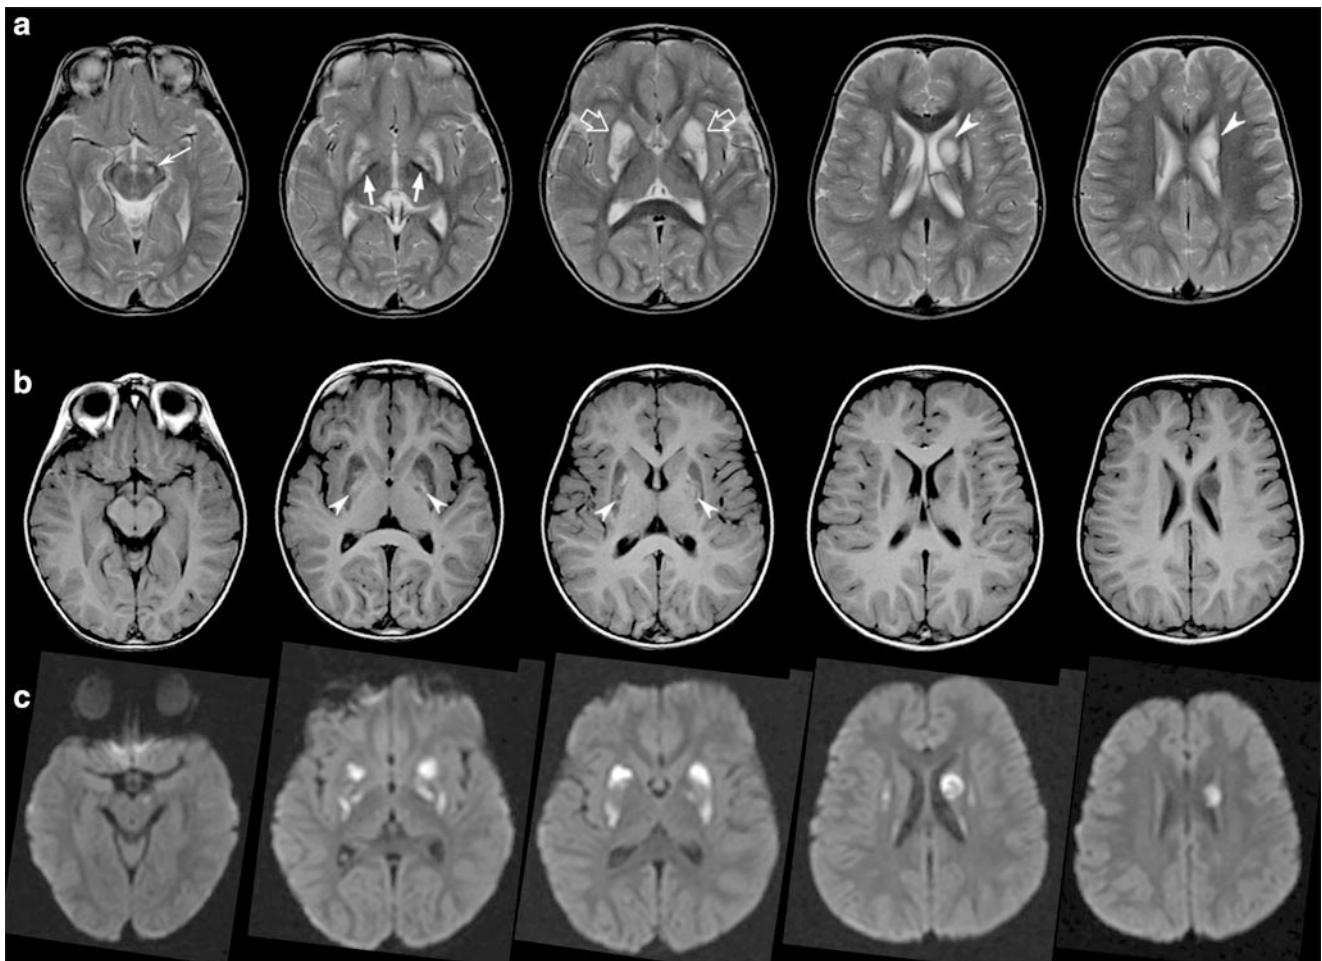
Brain MRI performed at 2 years and 8 months. (a) Axial T2-weighted images demonstrate symmetric swelling and T2 hyperintensity of the putamina (*empty arrows*) and asymmetric involvement of globi pallidi (*arrows*), left cerebral peduncle (*thin arrows*), and left caudate nucleus (*arrowheads*). Note that the lesion of the left caudate
